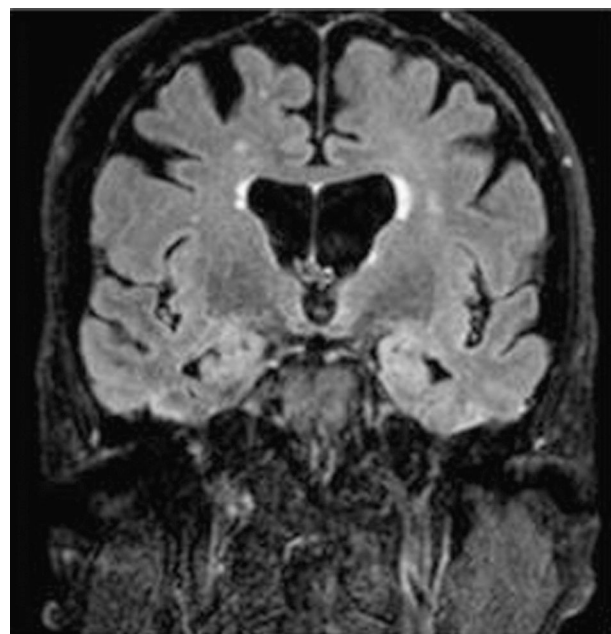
Brain MRI (FLAIR) scan: coronal section showing hyperintensity in both temporal lobes.
